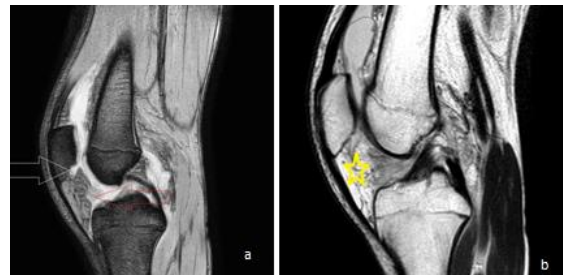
MRI right knee of 16-years old boy with trauma.(a) T1W thin sagittal sections show thickened infrapatellar plica (yellow horizontal arrow).(b) Proton density STIR sagittal section shows edema and fragmentation of fat pad (yellow arrow) with increased signal intensity in anterior cruciate ligament(saffron arrow).(c) Short tau inversion recovery (STIR) coronal section shows increase signal intensity on the medial femoral condyle suggestive of post traumatic marrow edema (white horizontal arrow).
